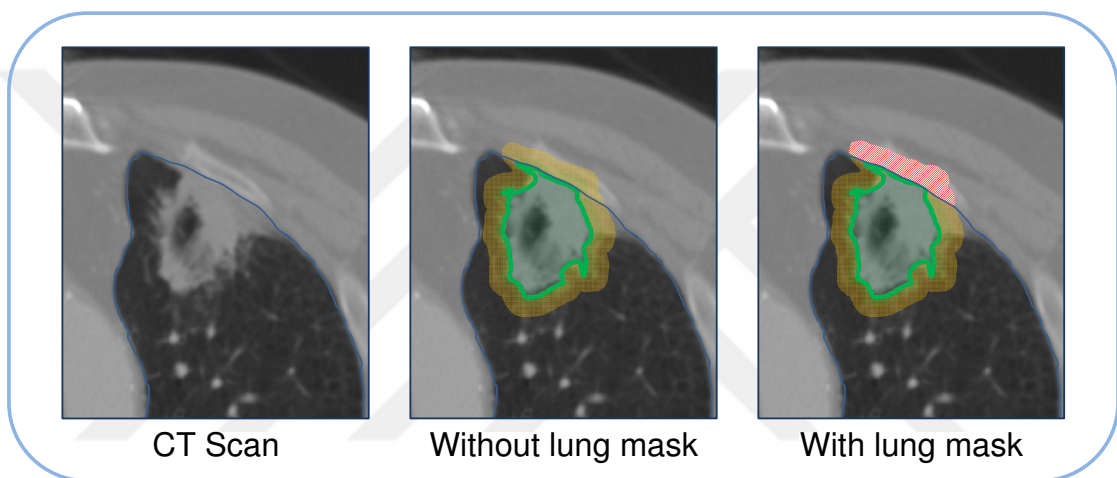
Peritumoral masks. Image on the left shows a CT scan ROI. Image on the middle image shows a peritumoral region that is not bounded by the lung parenchyma mask. Image on the right shows peritumoral region bounded by the lung parenchyma mask. Red region is removed from the peritumoral region as it lies outside the lung parenchyma.
